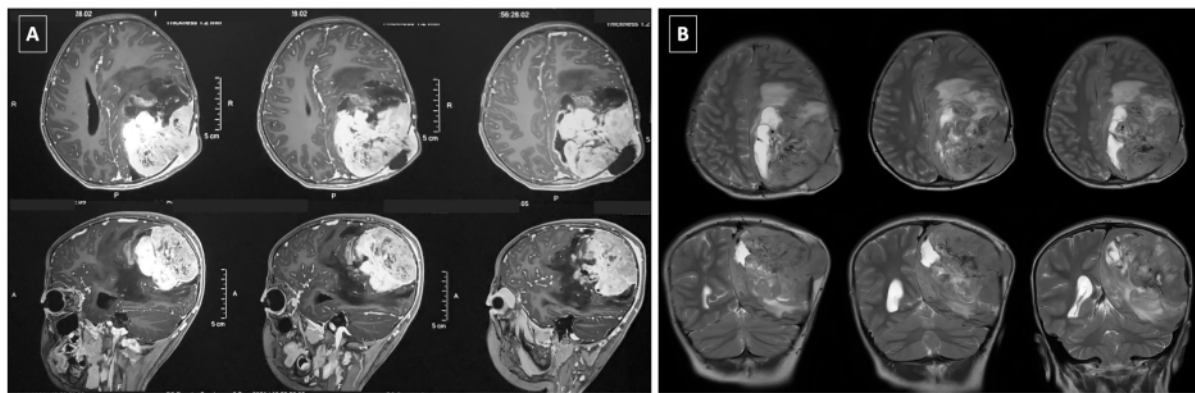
MR imaging at the presentation before performing the first surgical procedure. T1-weighted imaging with gadolinium (A) shows heterogeneous contrast enhancement in the left parieto-occipital tumor region. T2-weighted imaging (B) shows hyperintense in general (hemorrhagic areas can be hypointense).
